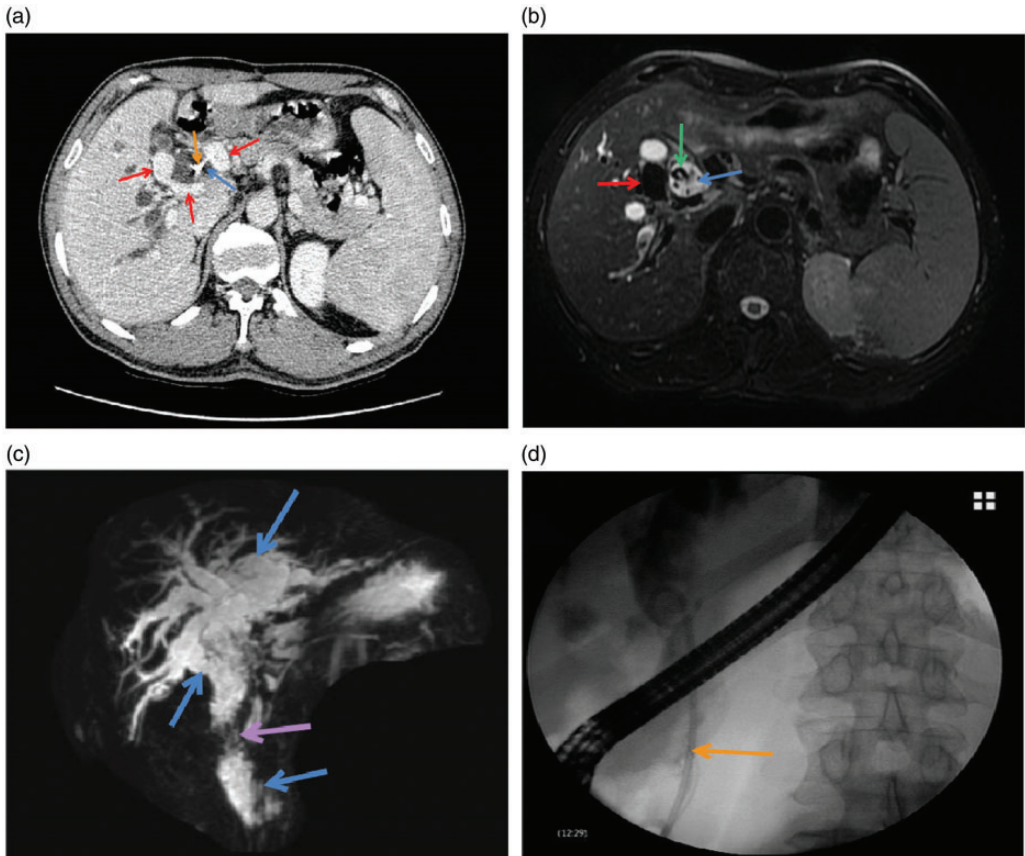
Computed tomography and magnetic resonance imaging + magnetic resonance cholangiopancreatography images reviewed prior to the most recent endoscopic retrograde cholangiopancreatography. (a) Computed tomography showed the dilated collateral pathway of the portal vein, partially enclosing the bile duct (red arrows). (a–c) The intrahepatic bile duct and common bile duct were dilated (blue arrows). (a) The drainage tube shadow could be seen in the common bile duct (yellow arrow). (c) Magnetic resonance cholangiopancreatography showed obvious expansion of the intrahepatic and extrahepatic bile duct and common bile duct (blue arrows), and the lower segment of the common bile duct was relatively narrow (purple arrow). (b) The collateral pathway of the portal vein was dilated, branched, and disorganized (red arrow), and a stone shadow could be seen in the common bile duct (green arrow). (d) In the most recent endoscopic retrograde cholangiopancreatography procedure, a new plastic stent was placed (yellow arrow).
